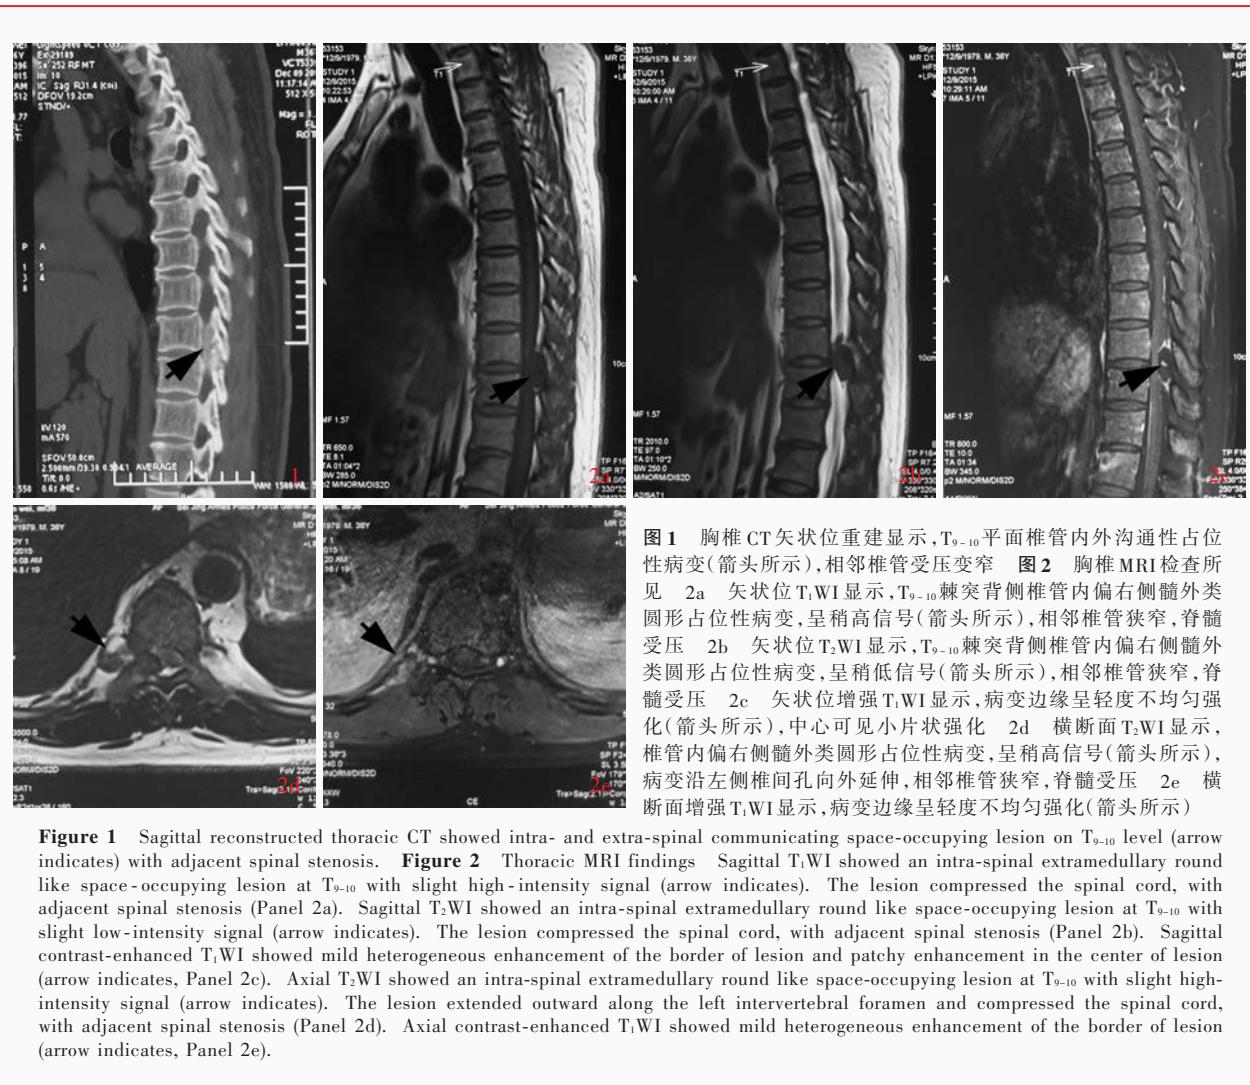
Sagittal reconstructed thoracic CT showed intra- and extra-spinal communicating space-occupying lesion on T₉₋₁₀ level (arrow indicates) with adjacent spinal stenosis. Figure 2 Thoracic MRI findings. Sagittal T₁WI showed an intra-spinal extramedullary round like space-occupying lesion at T₉₋₁₀ with slight high-intensity signal (arrow indicates). The lesion compressed the spinal cord, with adjacent spinal stenosis (Panel 2a). Sagittal T₂WI showed an intra-spinal extramedullary round like space-occupying lesion at T₉₋₁₀ with slight low-intensity signal (arrow indicates). The lesion compressed the spinal cord, with adjacent spinal stenosis (Panel 2b). Sagittal contrast-enhanced T₁WI showed mild heterogeneous enhancement of the border of lesion and patchy enhancement in the center of lesion (arrow indicates, Panel 2c). Axial T₂WI showed an intra-spinal extramedullary round like space-occupying lesion at T₉₋₁₀ with slight high-intensity signal (arrow indicates). The lesion extended outward along the left intervertebral foramen and compressed the spinal cord, with adjacent spinal stenosis (Panel 2d). Axial contrast-enhanced T₁WI showed mild heterogeneous enhancement of the border of lesion (arrow indicates, Panel 2e).
